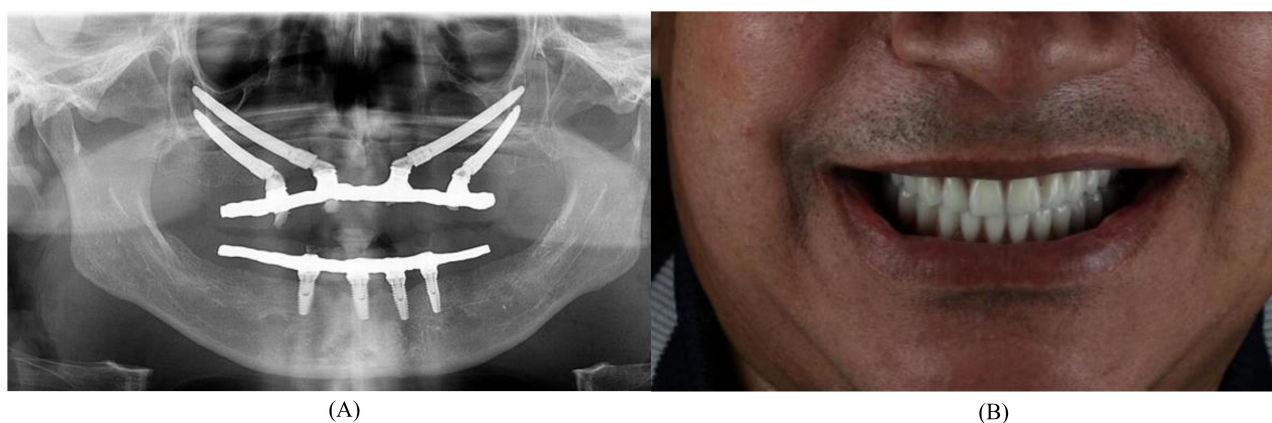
(A) Panoramic radiography; (B) Patient smile after prosthesis installation.
